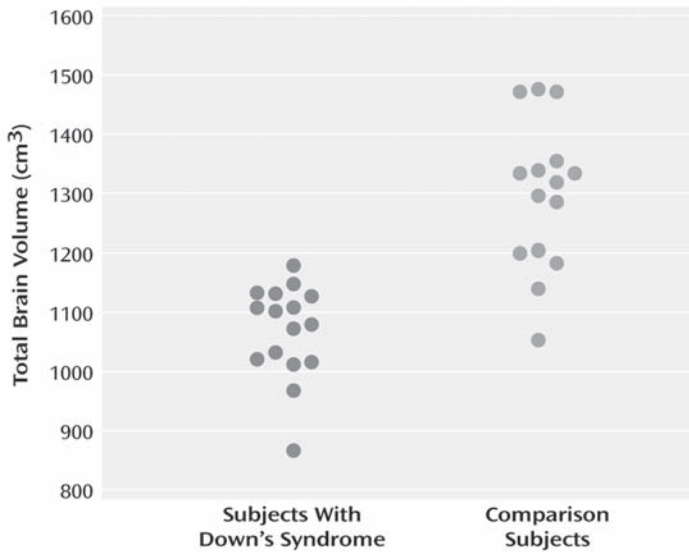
This graph shows results from a quantitative MRI study finding an 18% decrease in total brain volume in subjects with Down syndrome (DS) compared to normal controls. From Pinter et al. (2001). Copyright 2001 by the American Psychiatric Association. Reprinted by permission.
